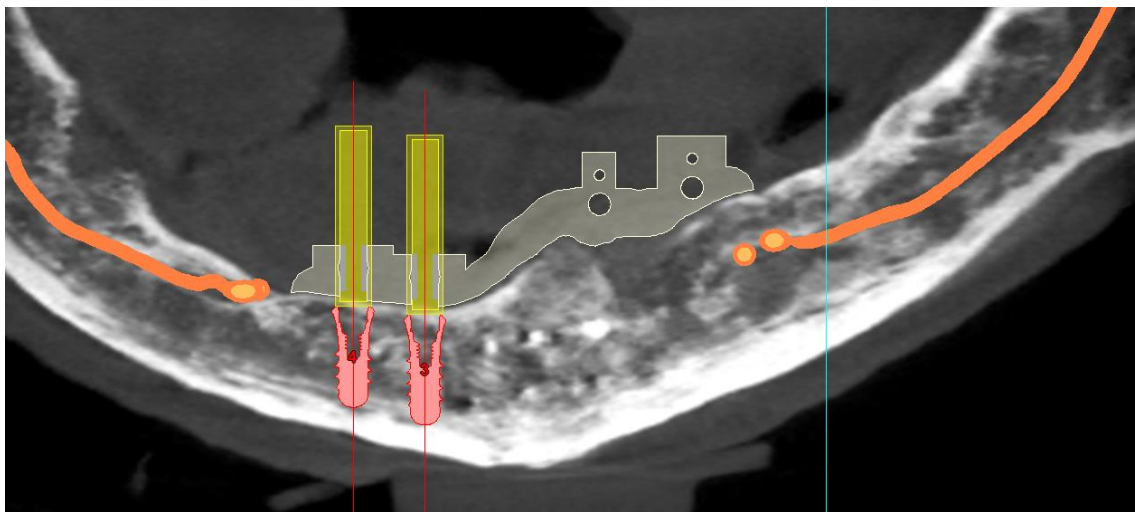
CBCT image segmented in digital planning software to highlight the inferior dental nerve and mental foramina (marked in orange) so these can be avoided when planning implant placement.
